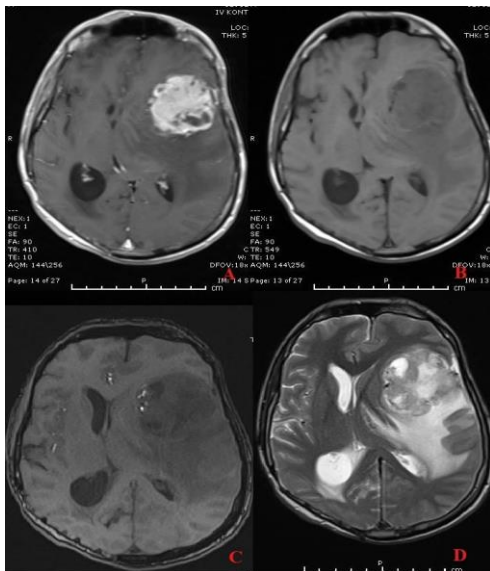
A 38-year-old man referred to us with three days' duration of difficulties in speech, changes in consciousness, and severe headaches. A contrast-enhanced MRI revealed a multilobulated heterogeneously intense enhanced tumor measuring 8.2x6.2x5.6 cm. The mass was located in the left frontotemporal region and surrounded by diffuse edema. The patient received gross total resection followed by RT for right parietal IEMC 18 years ago. Over 18 years, he had received multiple mandibular and maxilla surgeries and twice adjuvant RT for several metastases. [A]: Contrast-enhanced T1WIs revealed a multilobulated, heterogeneous, and intense enhanced tumor with distributed hypointense areas. [B]: T1WIs showed a mild hypointense lesion with a brimmed hypointense nodule. [C]: TOF-MRA images showed a hypointense lateral compartment. It resembles the nodule is seen in a high vascularized lesion. The medial component was a slight inhomogeneous iso-hypointense. [D]: T2WI showed heterogeneous hyperintense surrounded by diffuse vasogenic edema while the medial nodule was hyperintense.
